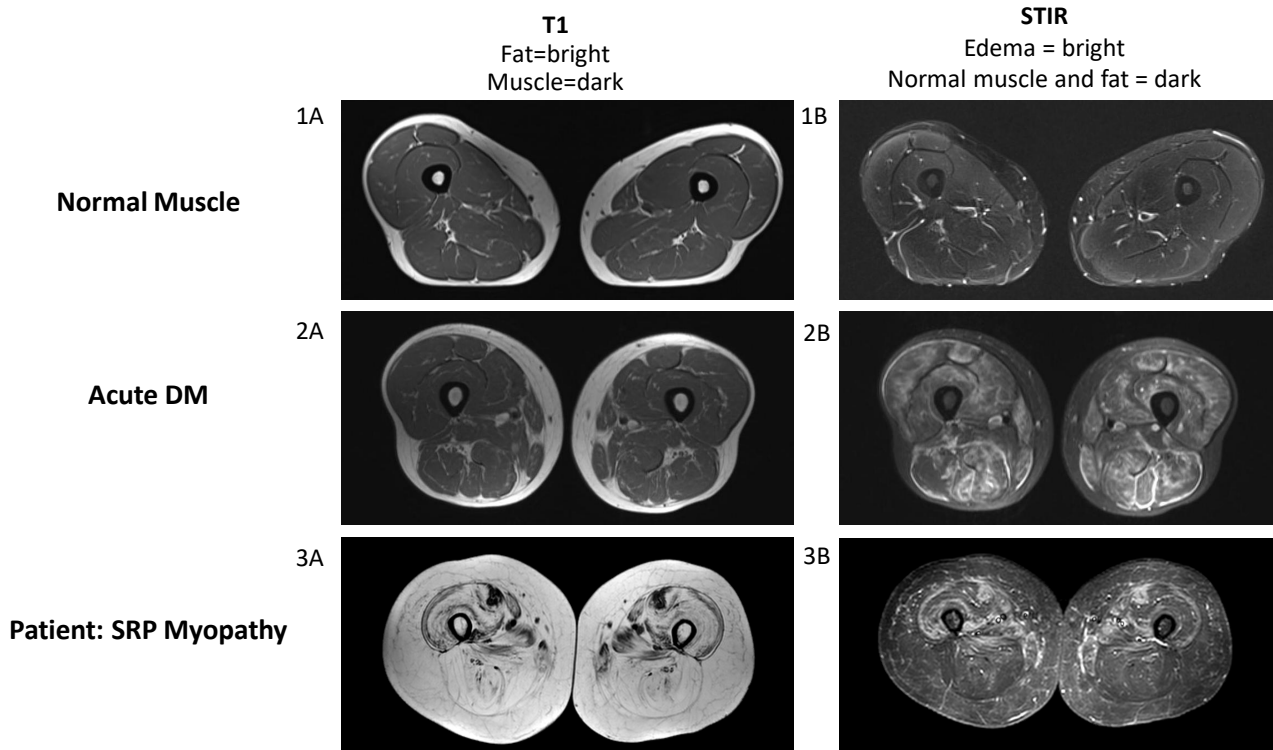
Muscle MRI of right and left thighs with comparison cases
